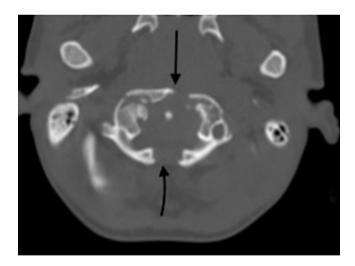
Axial computed tomography showing bifid anterior arch (straight black arrow) and bifid posterior arch (curved black arrow).
